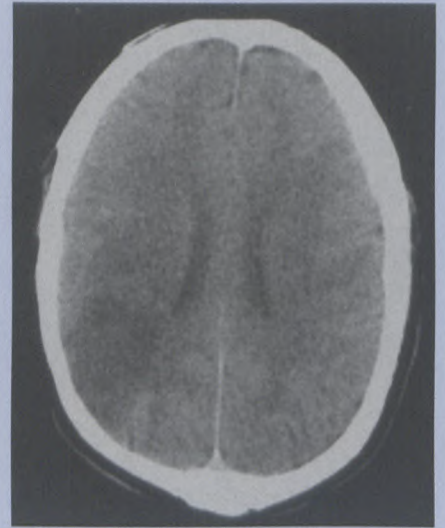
Unenhanced axial CT scan showing the area of infarction in the right parietal lobe.
